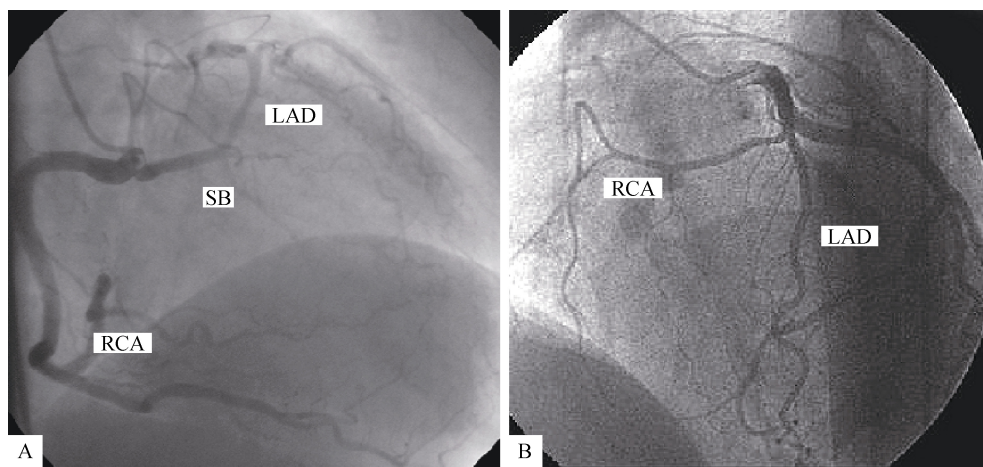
Single coronary artery. (A): origin of LCA from the RCA with septal course and absence of the LCx in a 70-year old female; (B): origin of RCA from the LAD with interarterial course confirmed by MRI in a 75-year old male. LAD: left anterior descending coronary artery; LCA: left coronary artery; LCx: left circumflex artery; RCA: right coronary artery; SB: side branch.
